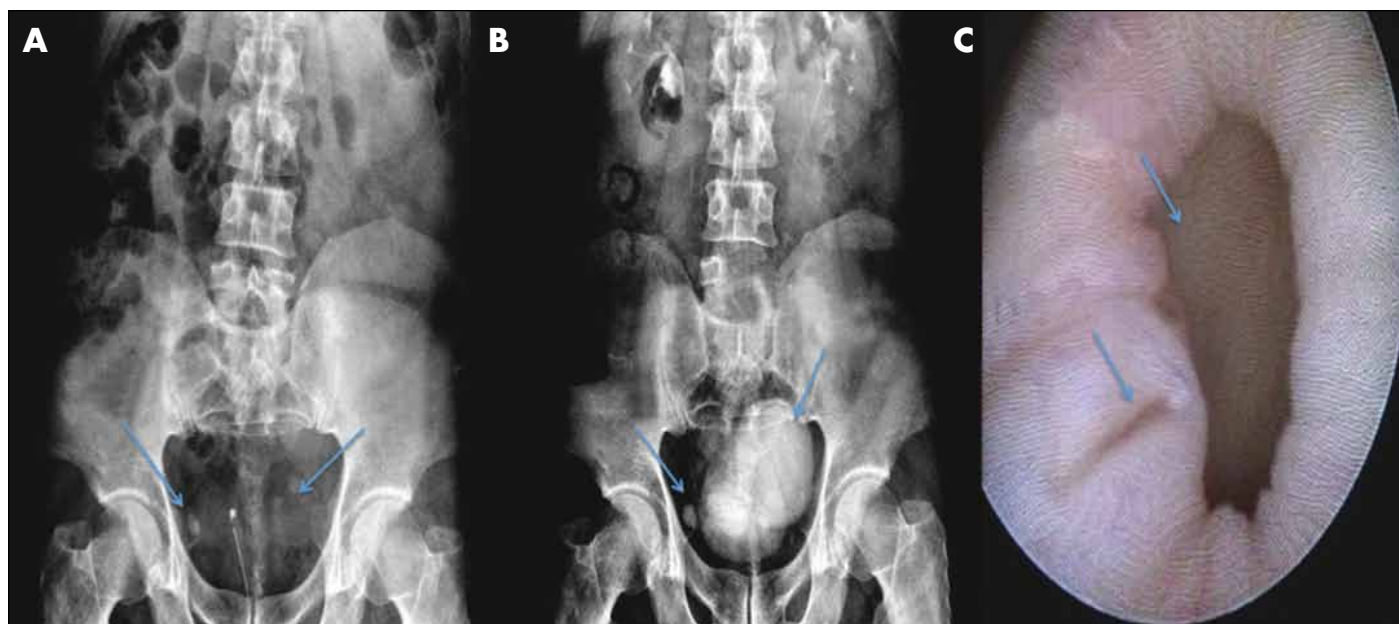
A: Plain abdominal radiography showing radiopaque stones in the bladder (arrows). B: Intravenous pyelogram revealing bilateral bladder diverticulum with 7 × 7 cm at left inferior and 1 × 2 cm at right inferior portion (arrows). C: Endoscopic view of ureterovesical junction bladder diverticulum (arrows).
